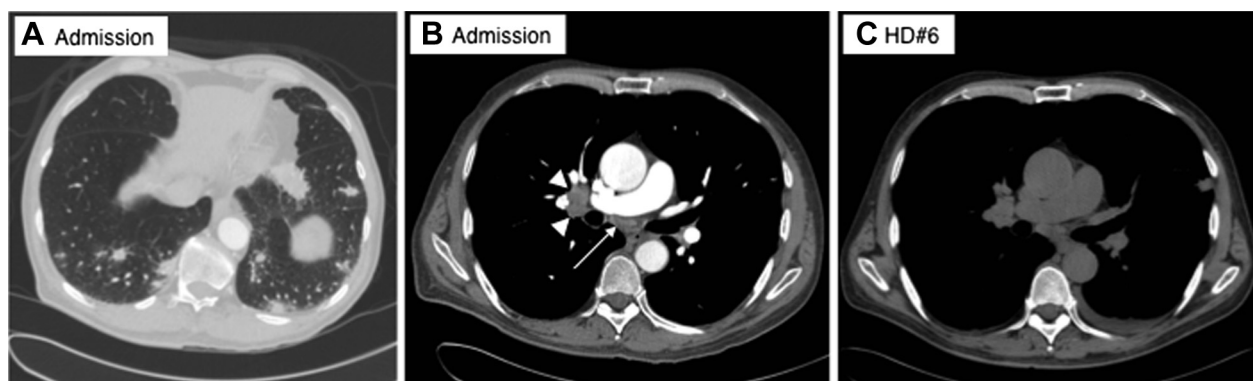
Chest CT scans. A, Axial chest CT image on admission shows bilateral nodular opacities in the lower lobes. B, Mediastinal window of the admission chest CT scan with contrast shows prominent right hilar (arrowheads) and modest mediastinal (arrow) lymphadenopathy. Less extensive hilar lymphadenopathy (not visible in current image) was also present on the left. C, Mediastinal window of a chest CT scan on hospital day 6 revealed a new, small pleural effusion on the left, with unchanged lymphadenopathy and, also, worsening of the bilateral nodular opacities (not seen in this image).
